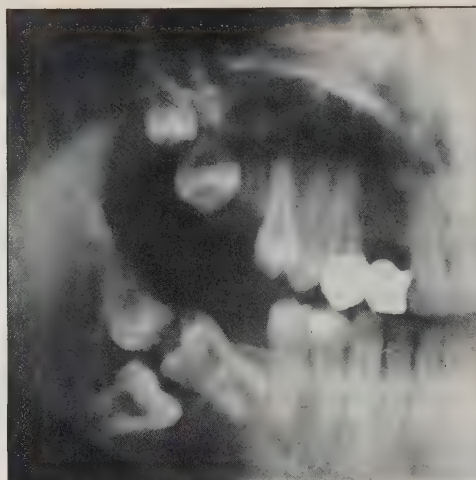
Panoramic radiograph of Case 1 from right to left. Note the unusual impaction of the lower right, first, second and third molars.
